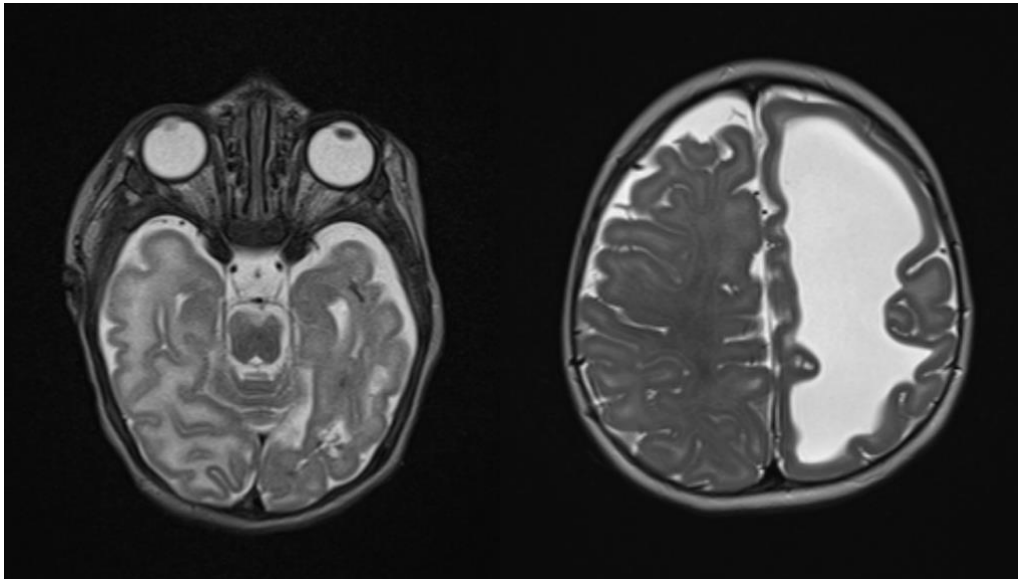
Perinatal hypoxic-ischemic encephalopathy with West syndrome: Brain MRI in a girl with severe hypoxic-ischemic perinatal encephalopathy. T2W axial in 2,5months of age (on the left) and T2W axial in 8 months of age.
